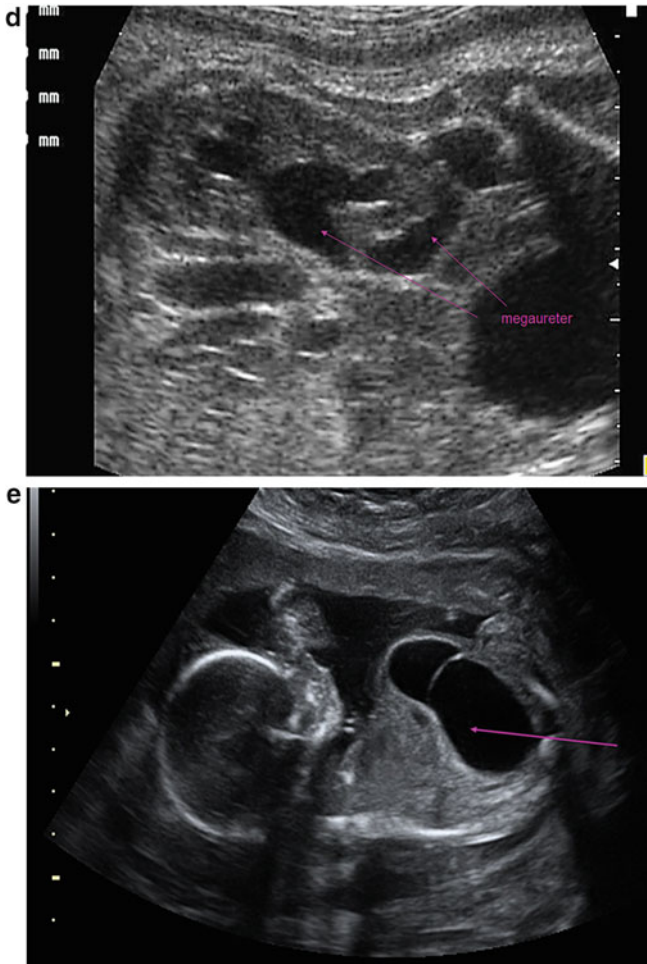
Ultrasound scanning of the fetal kidney and the urinary tract in normal and pathological situations (Gilles Grangé, personal data). (a) Normal appearance of fetal kidney at the end of pregnancy. Its outline is bumpy and corticomedullary differentiation is clearly visible. (b) Multicystic fetal kidneys with oligohydramnios. The kidney carries numerous irregular cysts on the periphery with a loss of corticomedullary differentiation and hyperechogenic appearance. (c) Renal dysplasia and oligohydramnios within a Meckel syndrome. The kidneys are large with a hyperechogenic appearance of the parenchyma due to renal dysplasia. It should look for associated encephalocele. (d) Obstructive megaureter. The ureter appears as a dilated tortuous fluid-filled tubular structure located between the bladder and the renal pelvis. (e) Severe megacystis at the first trimester. The urinary bladder is enlarged, full of urines, and occupies most of the fetal abdomen
